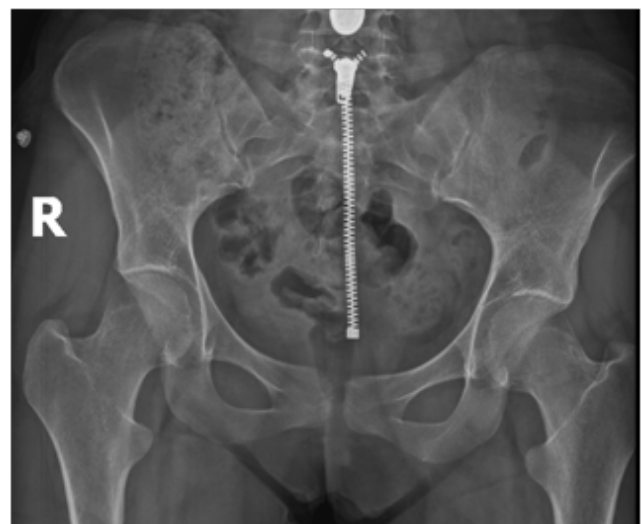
Pelvic AP X-Ray which shows no signs of fracture.
